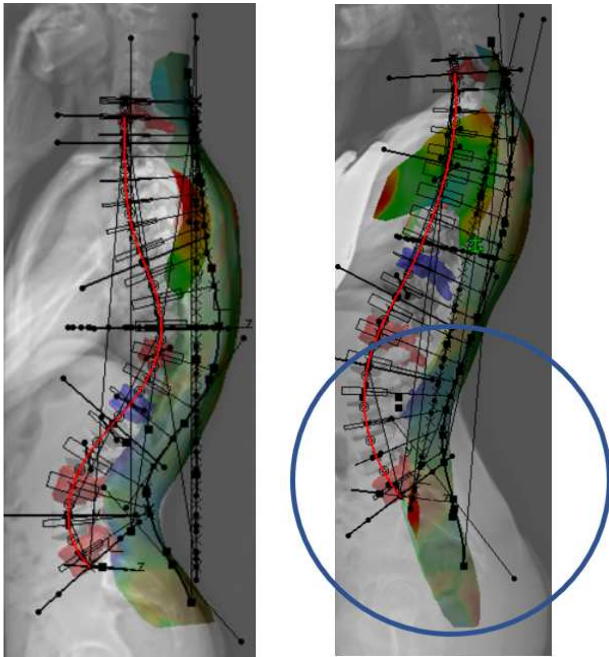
Fusion of two modalities (X-ray and 3D optical surface): Perfect matching (left); Mismatched fusion due to changed posture of the subject in sagittal plane (right)
